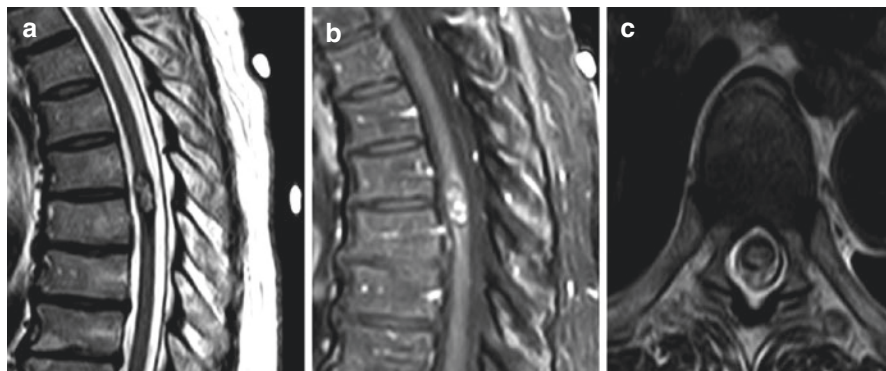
Spinal hemangioblastoma. (a) Sagittal T1-weighted post contrast MRI. (b) Sagittal T2-weighted MRI. (c) Separate example of sagittal T2-weighted MRI demonstrating extensive syrinx. (d) Cerebral angiogram demonstrated feeding vessels for hemangioblastomas
